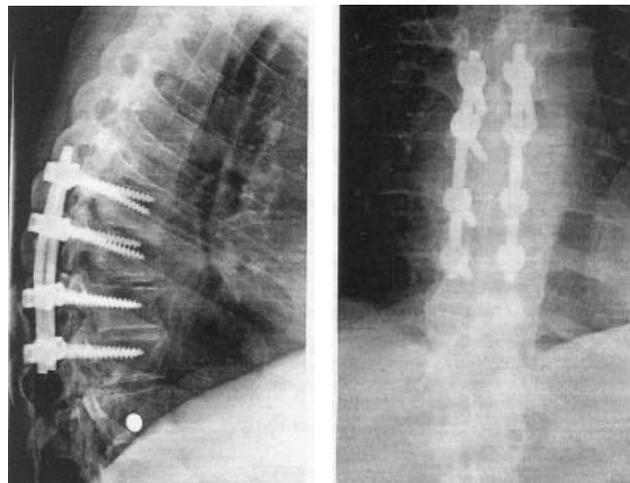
Postoperative X-rays showing stabilization with pedicle screws and rods two level above and below injury. Note the flowing osteophytes in the lower thoracic spine predominantly on the right side.
